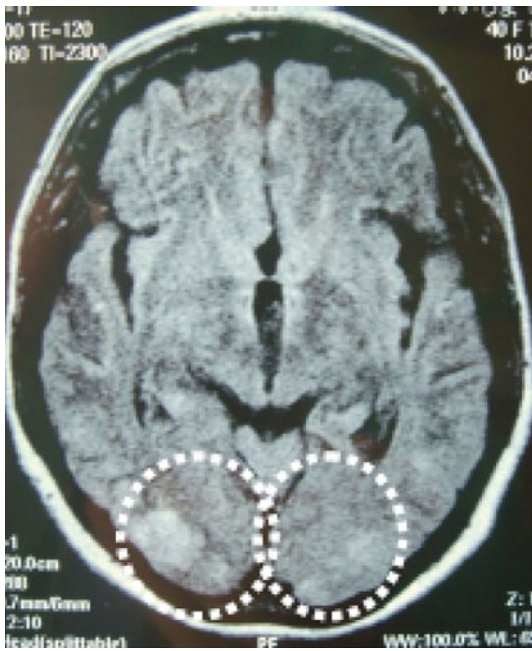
On POD 22, flair MRI demonstrated high-intensity regions (*encircled*) in the bilateral posterior occipital lobe
